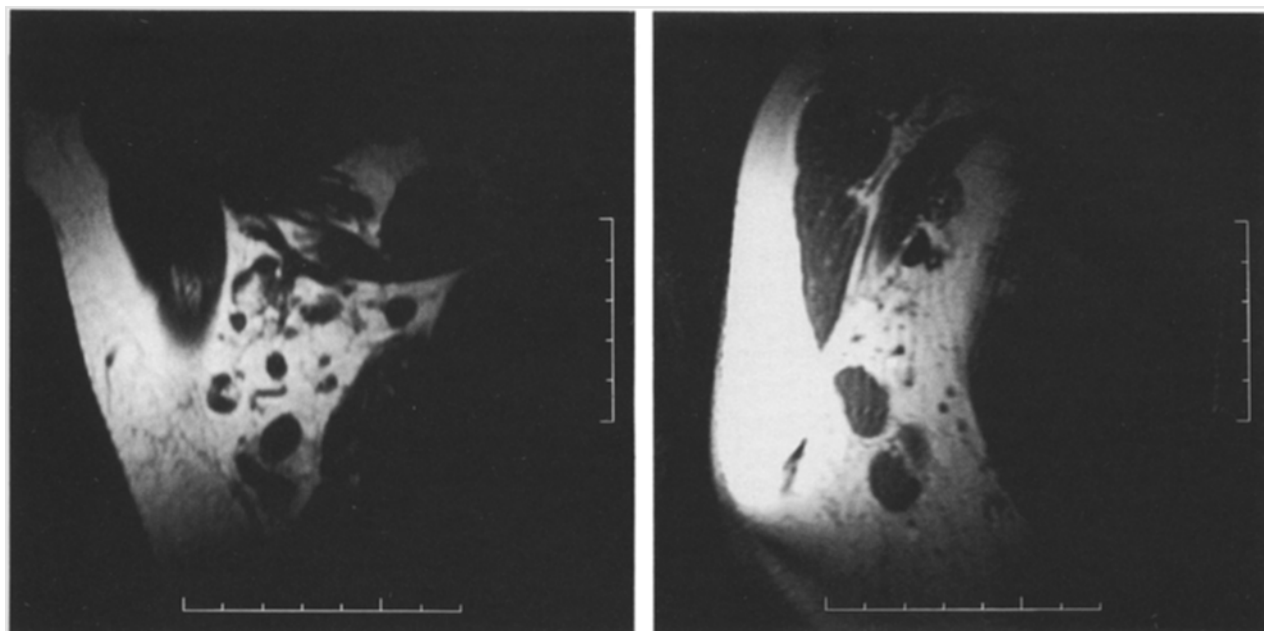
Axillary lymph node metastases in a 47-year-old woman. Left, Coronal T1-weighted spin-echo image. Right, Slightly angulated sagittal T1-weighted image. Images show multiple lymph nodes ranging from 3 mm to 20 mm in size at level I and II.
